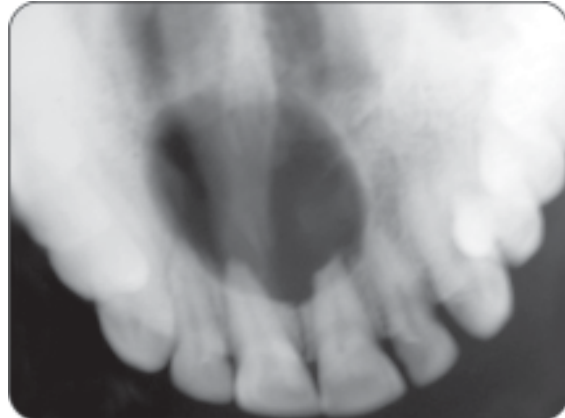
Radiograph of nasopalatine duct cyst
